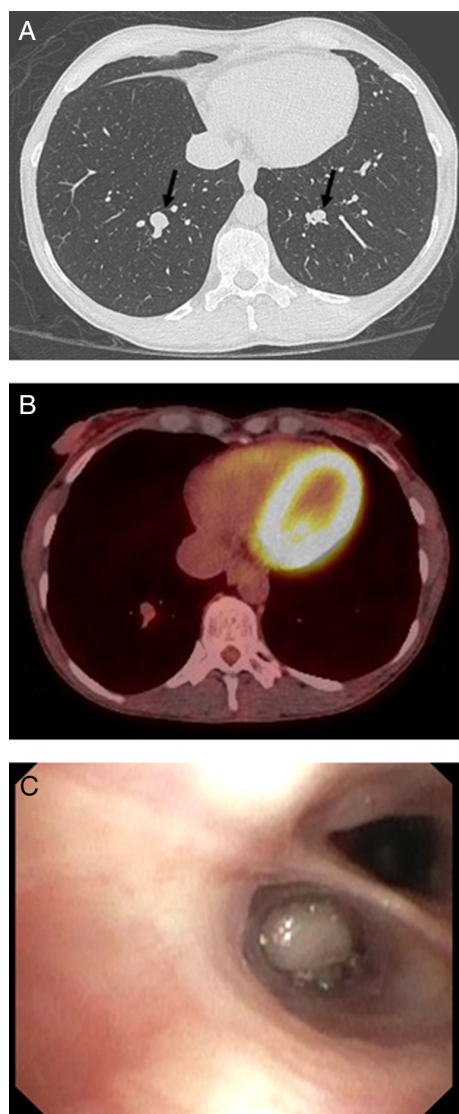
Imaging and bronchoscopic features. (A) Bilateral non-spiculated bronchocentric pulmonary nodules (arrows). (B) Low FDG avidity on PET imaging. (C) Smooth, firm white endobronchial tumours almost completely occluding the bronchus.
